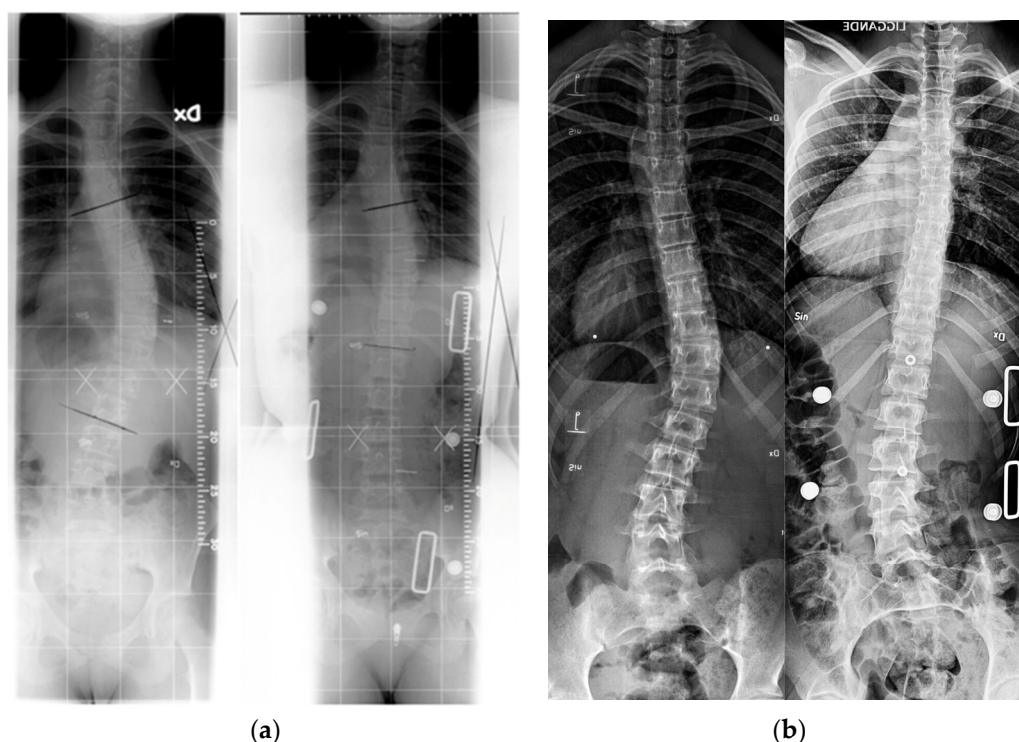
Pre-brace and in-brace radiographs for Boston and Providence brace treatments: (a) left: pre-brace (40° curve); right: in Boston brace (17°); (b) left: pre-brace (31° curve); right: overcorrection in Providence brace (-4°).
